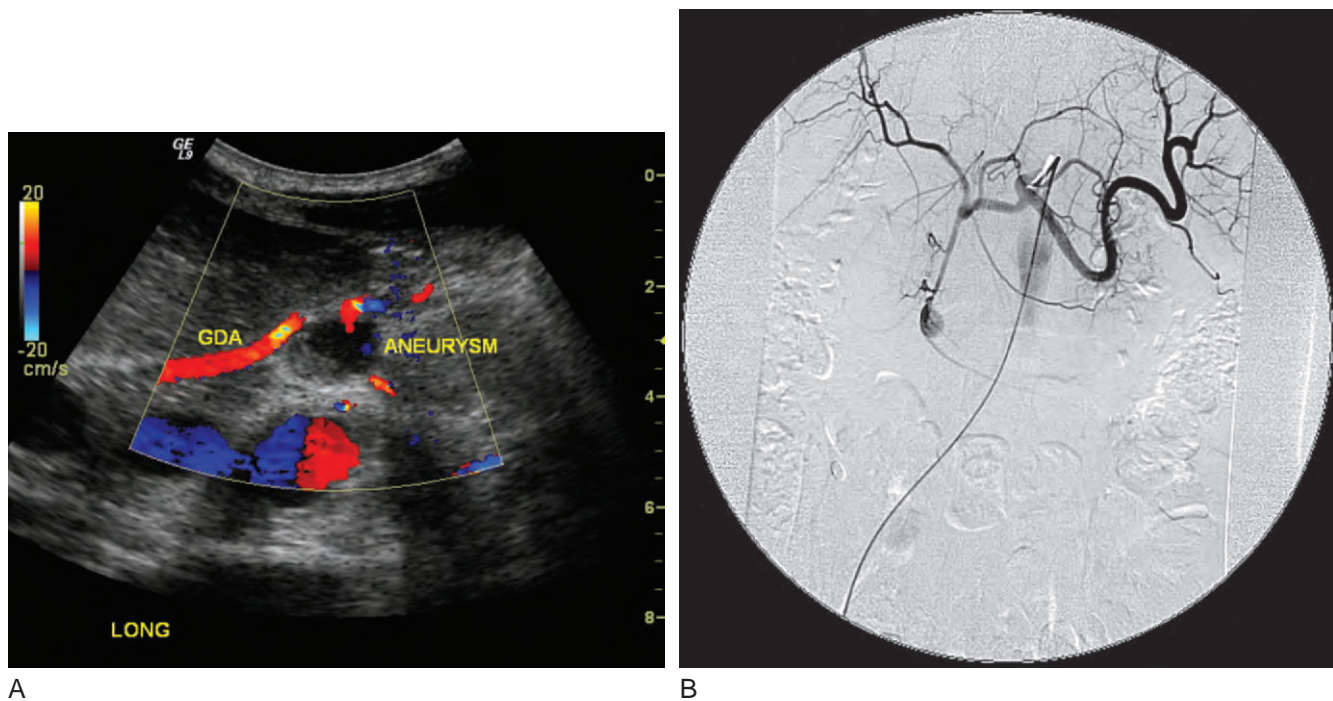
A, A longitudinal abdominal color duplex ultrasound demonstrates an aneurysm of the gastroduodenal artery (GDA) and an echogenic thrombus within it. B, Selective angiography of the celiac trunk shows the aneurysm with retained contrast in the distal portion of the gastroduodenal artery.
